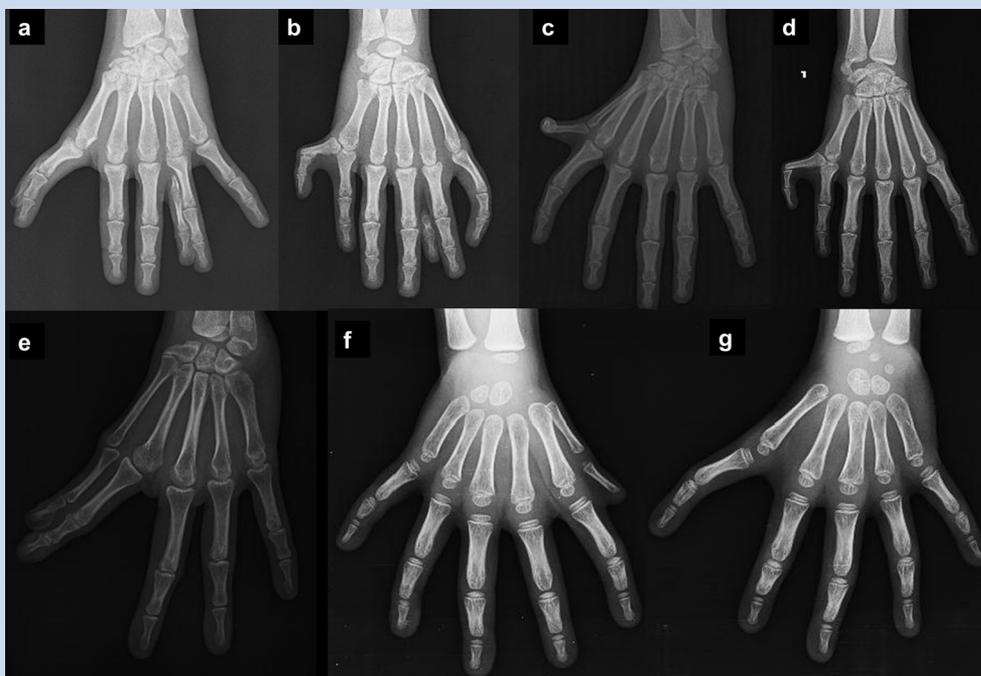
Hand radiographs of various phenotypes: (a) preaxial and mesoaxial polysyndactyly involving the phalanges (Individual IV:2), (b) central polysyndactyly and postaxial polydactyly involving the phalanges (Individual IV:2), (c) preaxial polydactyly involving the metacarpals (Individual IV:3), (d) postaxial polydactyly involving the phalanges (Individual IV:4), (e) complete cutaneous syndactyly of F1,F2 (Individual III:12), (f) preaxial polydactyly type B (Individual III:18), (g) triphalangeal thumb (Individual III:18).
